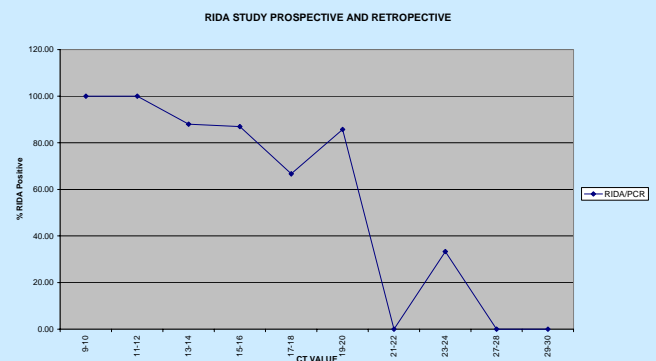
Comparison of CT value to RIDA®
